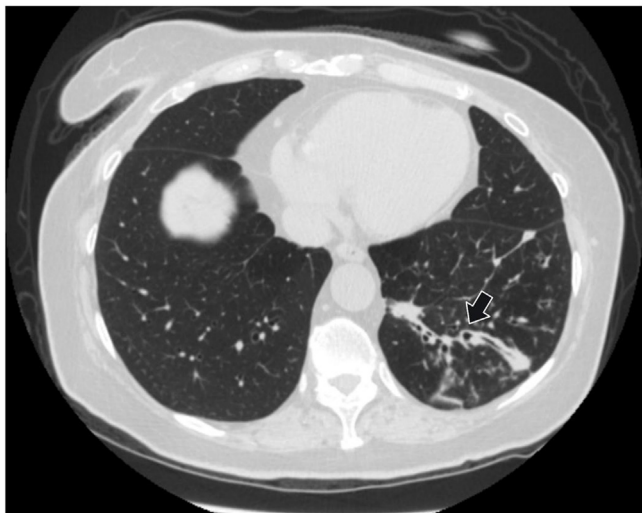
First CT examination reveals bronchiectasis and peribronchovascular thickening on left lower lobe of the lung (arrow).
